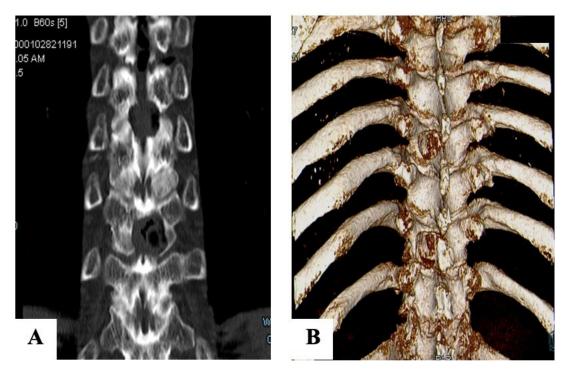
CT-Scan Coronal image (A) and 3D reconstruction of thoracic spine (B) showed decompression in two positions
